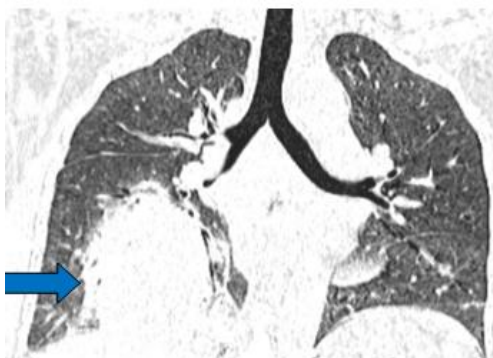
HRCT of the chest (lung window, coronal view) showing a large 7.5 x 7.4 cm sized well defined thick walled lesion(Blue arrow) in the posterior basal and medial basal segments of the right lower lobe with surrounding consolidation
